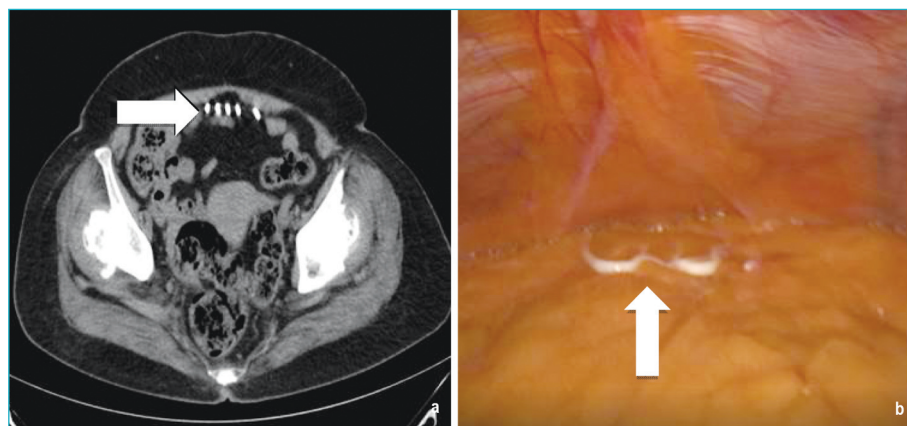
a) Lippes loop (showed by arrow) close to the anterior abdominal wall on computed tomography;
